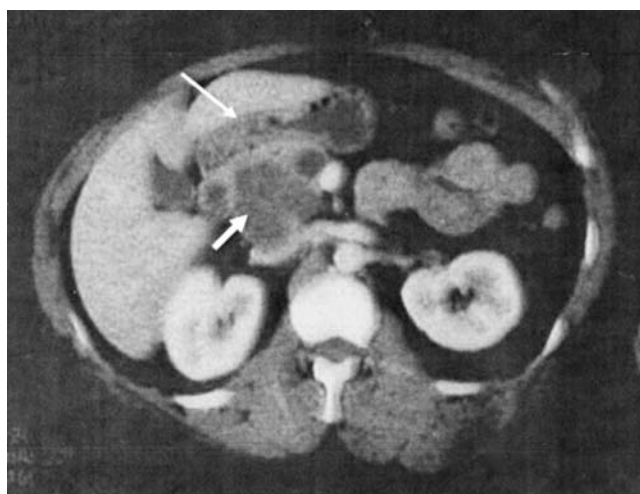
Abdominal CT of a 47-year-old woman who presented with abdominal pain and was found to have a cystic lesion in the head of the pancreas (*wide short arrow*). This mass closely abutted the proximal duodenum and pylorus (*narrow long arrow*), necessitating a classic pancreaticoduodenectomy for complete resection. Final pathology revealed a benign serous cystic neoplasm.
